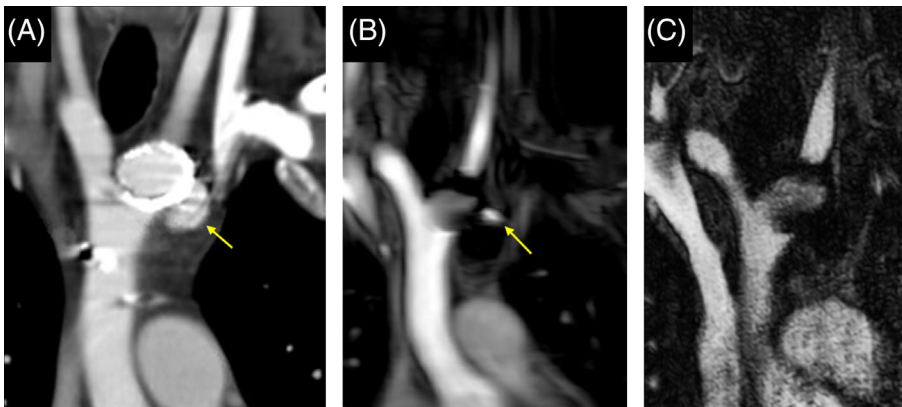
Serial imaging of the proximal aorta in a coronal plane. Part (A) shows the pseudoaneurysm (yellow arrow) prior to coil embolization on CTA. Magnetic resonance angiography (MRA) after the first coiling procedure (B) showed residual contrast filling in the cranial part of the aneurysm sac (yellow arrow). After additional coiling, no residual contrast filling was observed on follow-up MRA (C). CTA, computed tomography angiography [Color figure can be viewed at wileyonlinelibrary.com]
